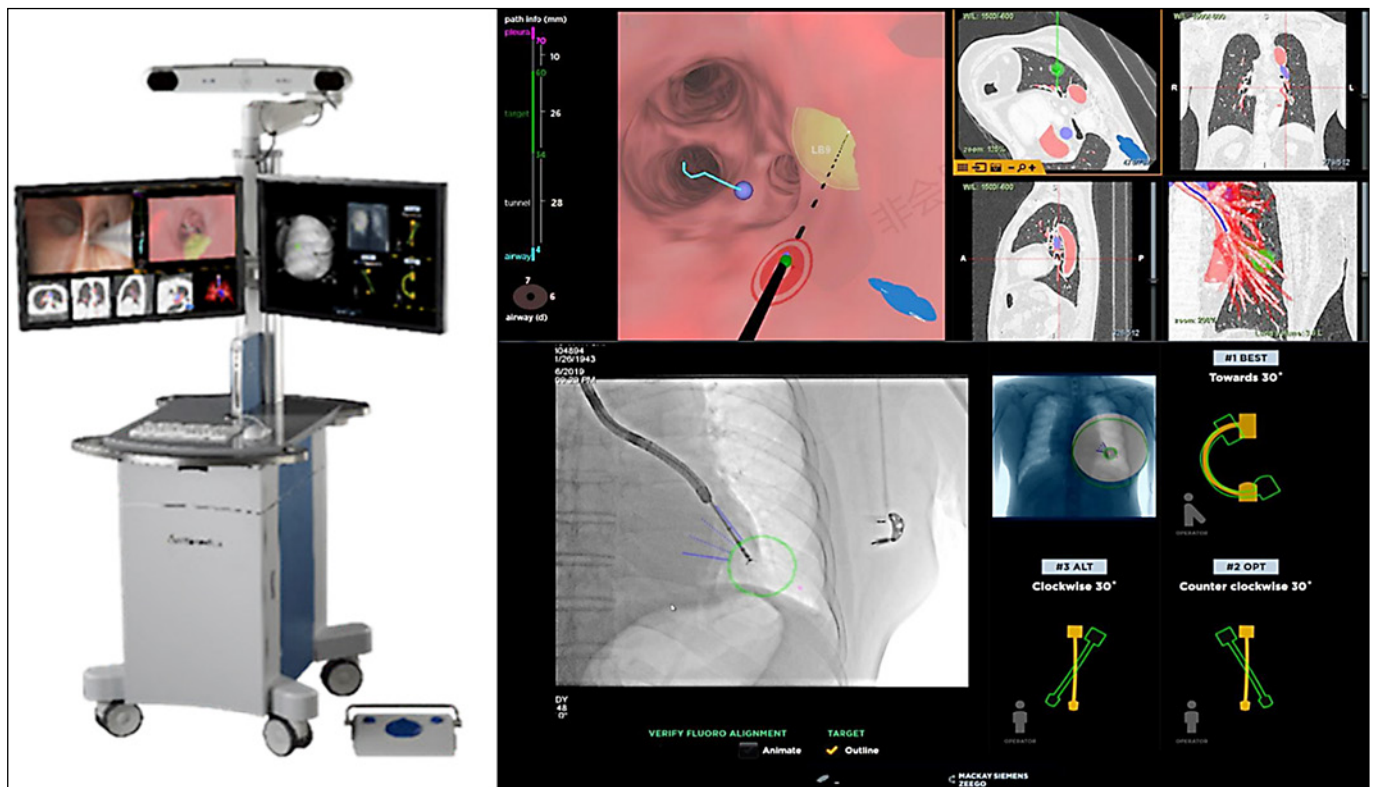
The Archimedes platform for transparenchymal nodule access. Archimedes display showing tunneling entry point and virtual Doppler, 3D CT reconstructions, and fused fluoroscopy with tunneled forceps at biopsy site.
